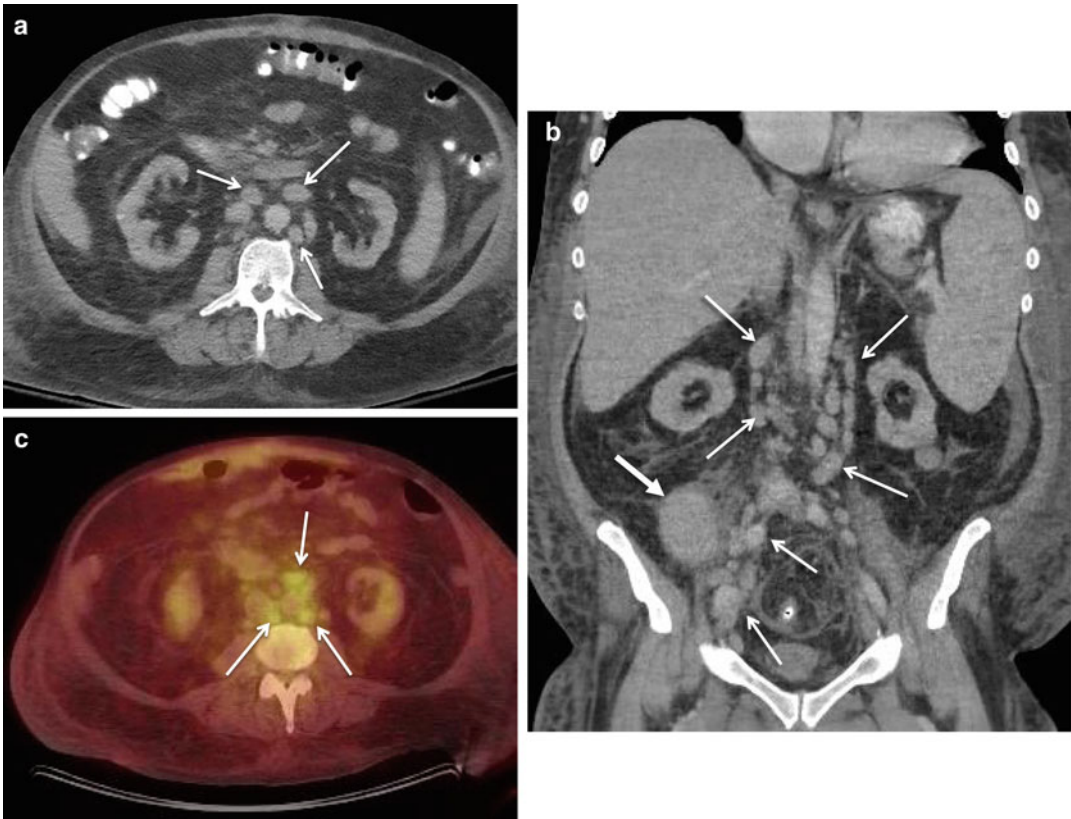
CT of PTLD manifesting as lymphadenopathy. (a) Axial postcontrast CT image reveals multiple mildly enlarged retroperitoneal lymph nodes (*arrows*) in a patient with PTLD. (b) The corresponding coronally reformatted image shows the retroperitoneal lymphadenopathy, pelvic
